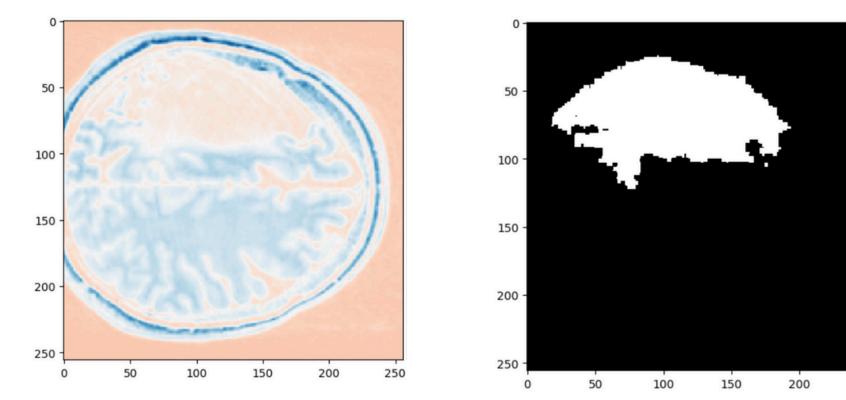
An example of high-resolution T1-weighted structural MRI scan of a patient post-stroke and the manually segmented diverse lesion.
